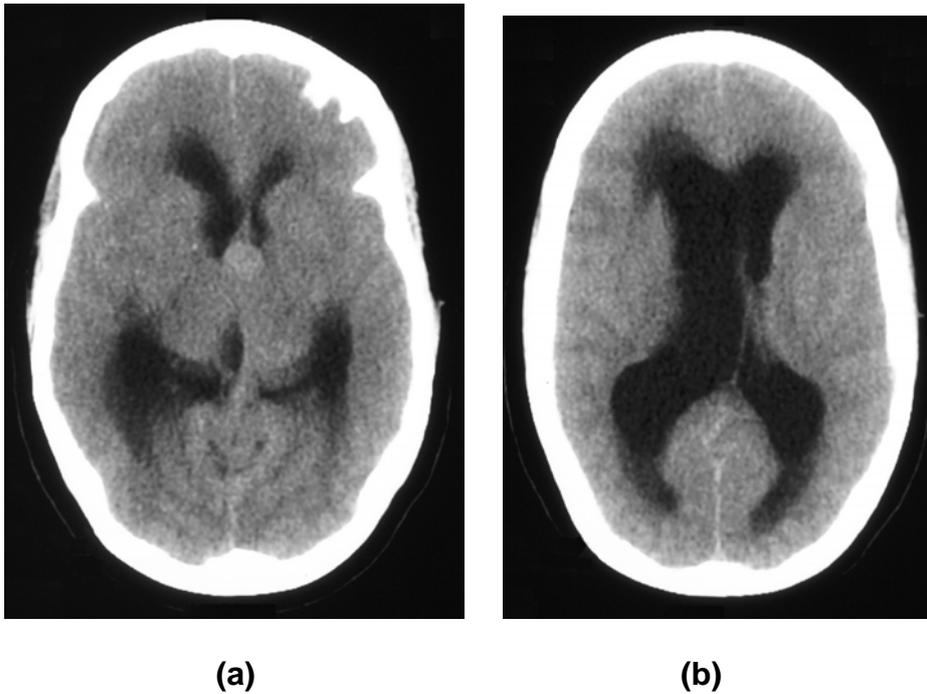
and 1b (Initial Head CT Scan)
